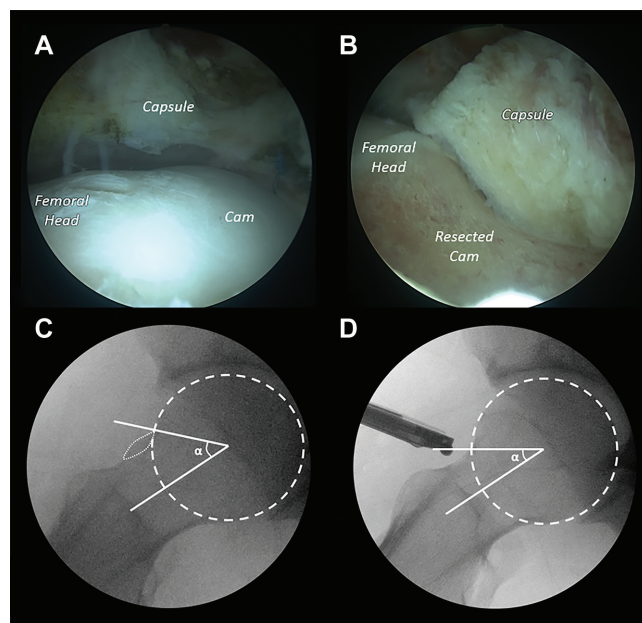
Intraoperative views of (A) cam morphology and (B) after cam resection. Fluoroscopic Dunn views demonstrating (C) preresection cam (fine dotted line) and associated increased α angle ($>50^\circ$) and (D) subsequent postresection radiographic absence of cam and normalization of α angle. Femoral head marked as coarse dotted line.
